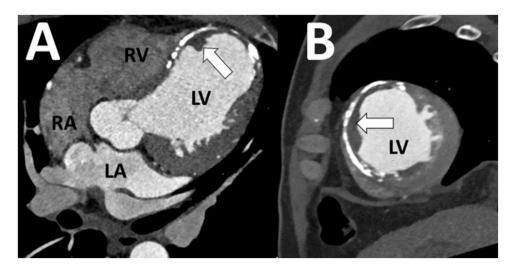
A 63-year-old man was referred for CCTA to evaluate coronary artery bypass graft patency. Four chamber view (A) and short axis view (B) CCTA demonstrated incidental found left ventricular thrombus (arrows) adhere to the thin calcified left ventricular myocardium. (CCTA : Cardiac computed tomography angiography, RA : Right atrium, LA : Left atrium, RV : Right ventricle, LV : Left ventricle).
